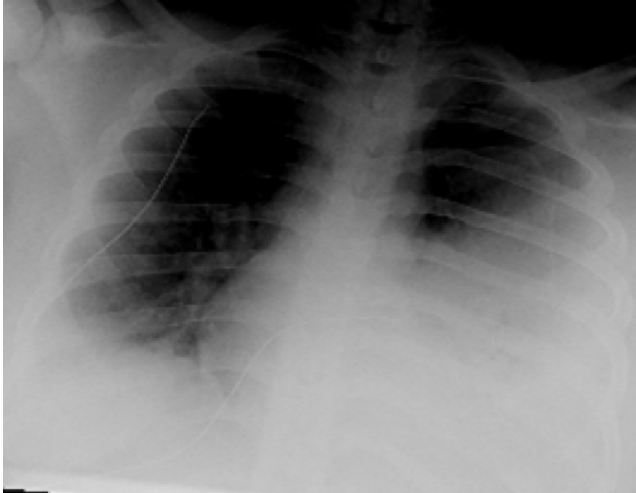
Radiograph of a child with pneumonia and pleural effusion caused by *Staphylococcus aureus*, complicating influenza.
